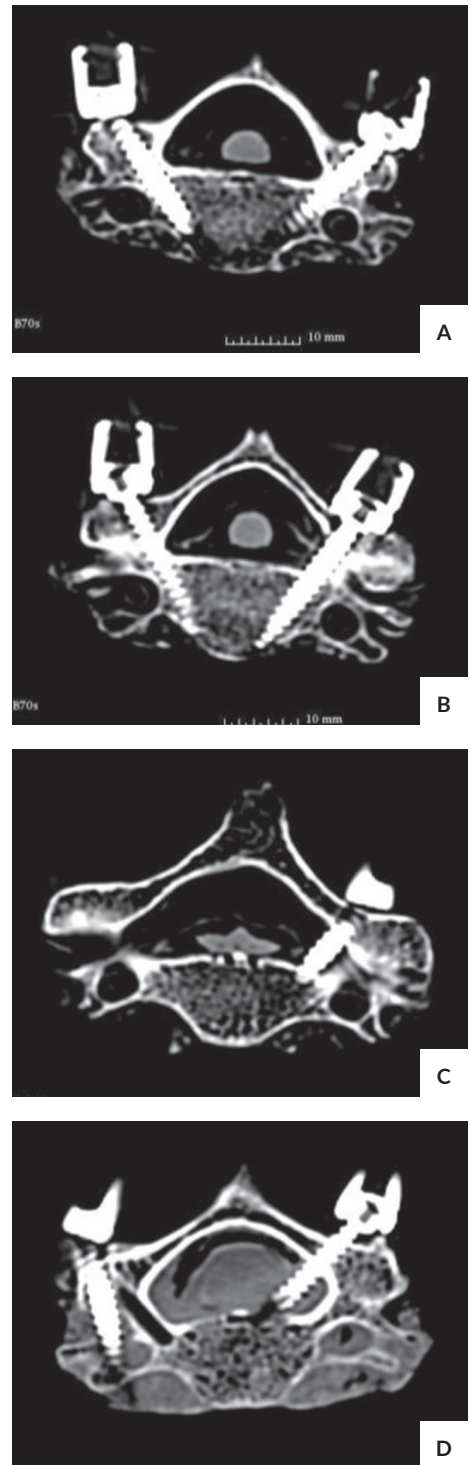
Post-instrumentation CT scans showing accuracy of CPS insertions: (A) Grade 0 for Spine A, level C4, both sides; (B) Grade 1 for Spine A, level C5, right side; (C) Grade 2 for Spine B, level C5, left side; (D) Grade 3 for Spine C, level C4, both sides.
